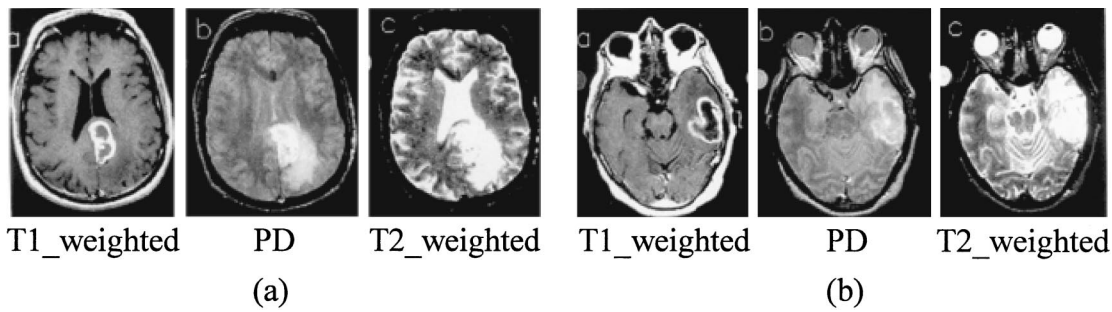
An example of an abnormal brain MRI. (a) br1 MR images (128×102); (b) br2 MR images (128×104).
